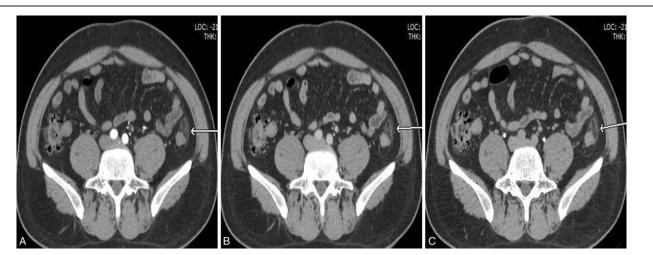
Axial CT images of the patient. A slightly high density shadow with fat foci in the middle beside the local descending colon, accompanied by the adjacent peritoneal thickening. A, B, C stands for the arterial phase, venous phase, and delayed phase, respectively. The arrow points to the PEA.
